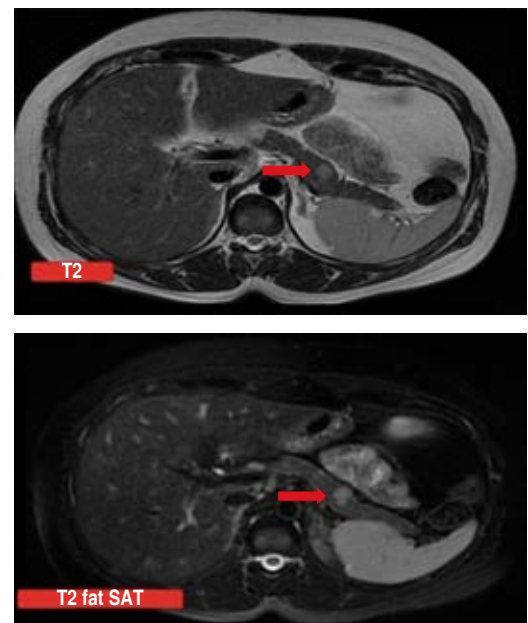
Gadolinium-contrast MRI in a T2 and fat T2 sequence showing a 12.2 × 9.7 mm tumor lesion in the pancreatic body.
